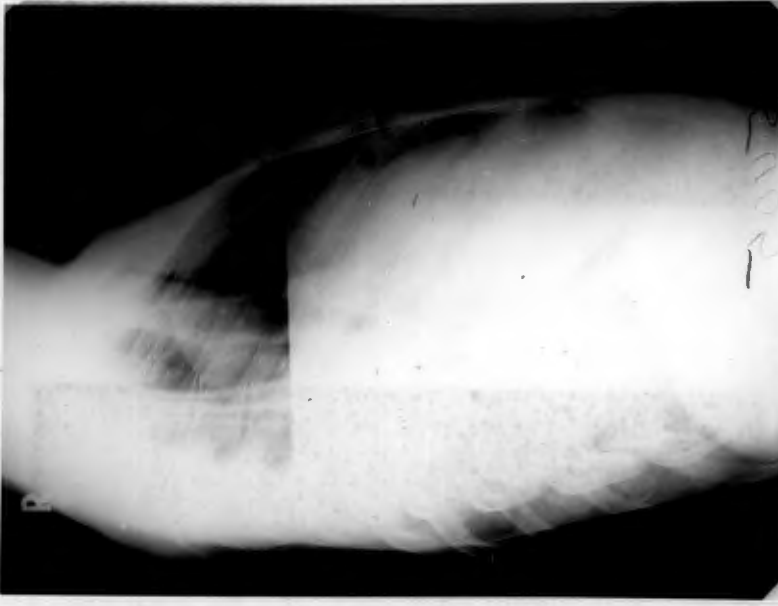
Case 46 Postero-anterior radiograph showing a large right sided effusion in a patient with an amoebic empyema.
